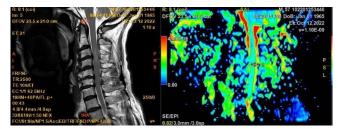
T2WI MRI and DTI-scan of cervical spine
